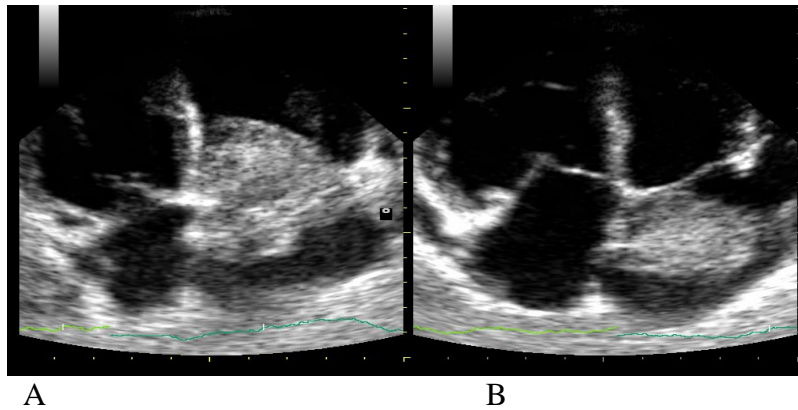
Parasternal Long Axis View of Echocardiogram Showing Left Atrial Myxoma Prolapsing into Left Ventricle Through Mitral Valve During Diastole
